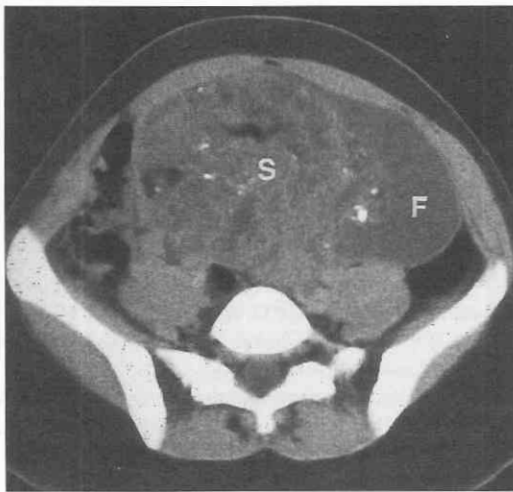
Malignant teratoma. CT scan through pelvic mass that contains fluid (F) and a complex solid component (S) that contains small areas of fat and calcification indicating malignancy.
